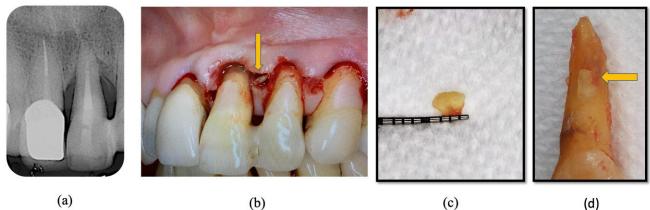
Example of the classification of cemental tears - Class 5. (a) Periapical radiograph of tooth 21 splinted to the adjacent tooth presented with vertical crestal bone loss at the mesial and distal aspects, in association with cemental tear and persistent deep periodontal pockets in spite of non-surgical periodontal therapy; (b) intra-surgical inspection of 21 confirmed the presence of cemental tear (arrowed); (c) a torn cemental fragment removed; and (d) direct inspection of the root surface with cemental tear of extracted 21. Courtesy of Dr Ian Lai.
